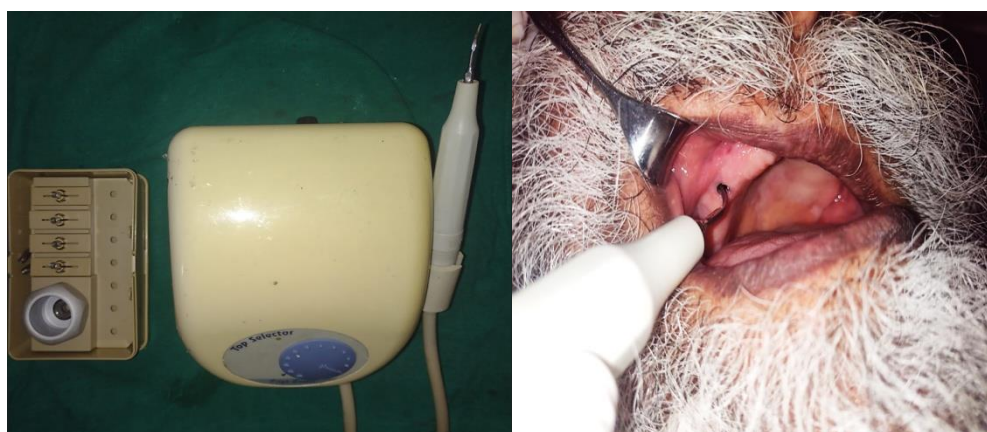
Ultrasonic Scaling Unit with sickle shaped scaler tip was used to retrieve the fractured segment
